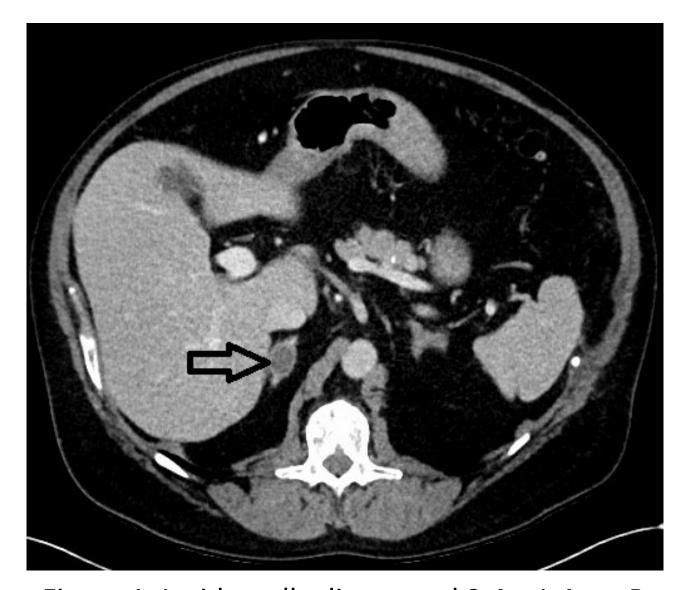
Incidentally discovered 2.4 x 1.4 cm R adrenal nodule (black arrow) on abdominal CT that prompted initial workup
